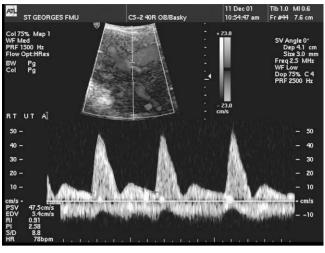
Abnormal uterine artery Doppler. Note the diastolic notching.
